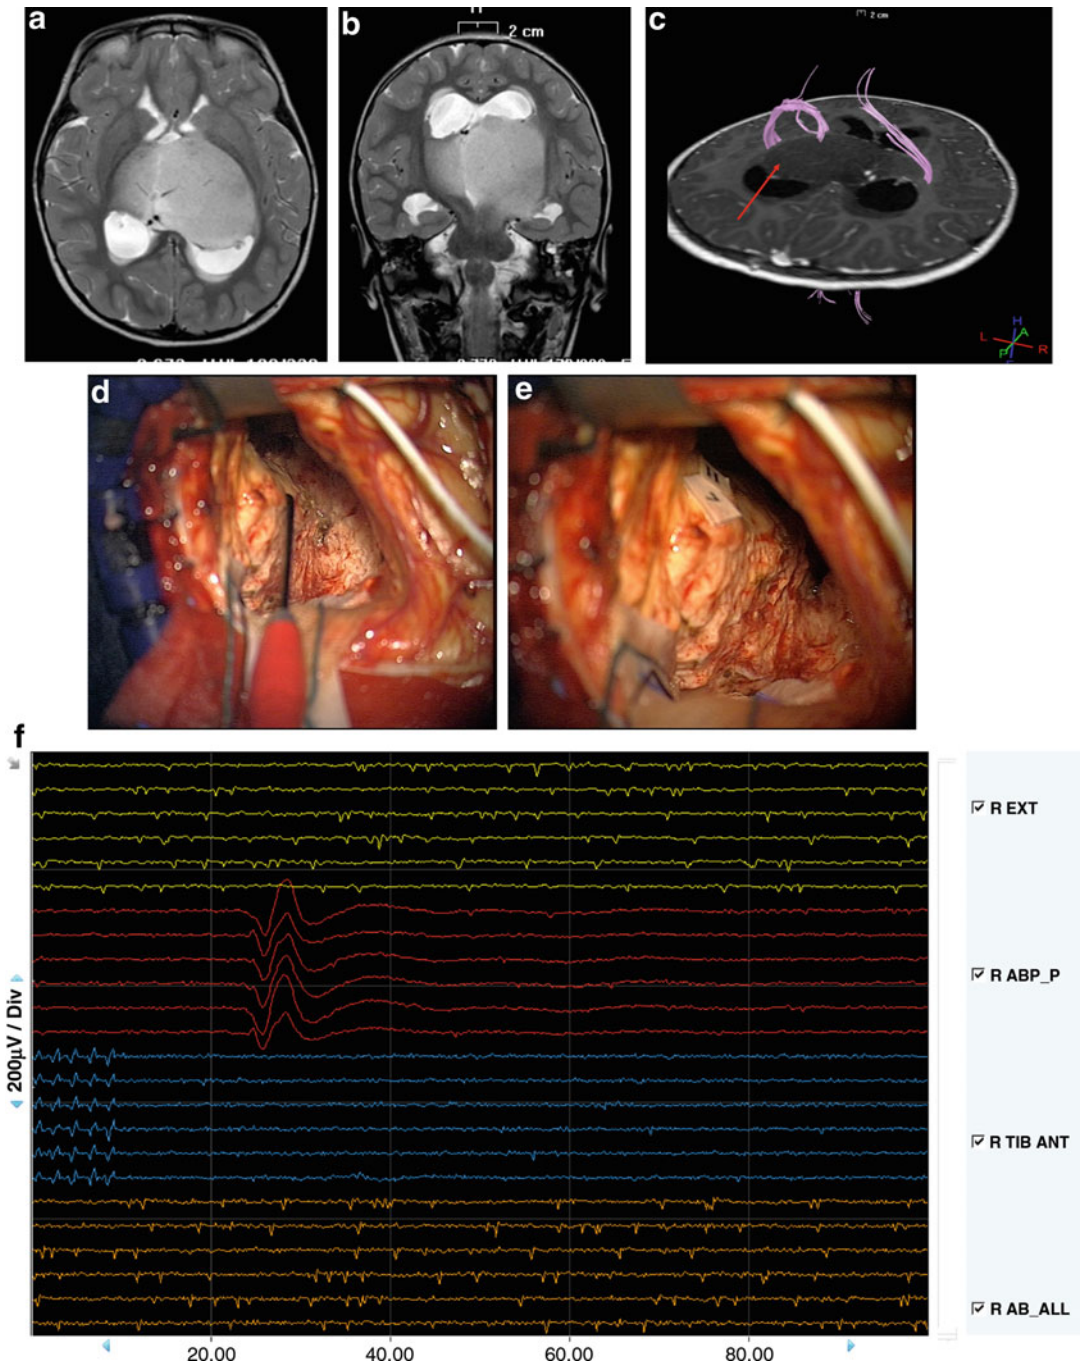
(a–b) A T2-weighted MRI (axial and coronal views) showing a large bilateral thalamic tumor in a 2-year-old girl, who presented with a progressive history of delayed milestones achievement, mild right hemiparesis, and tremor on the right upper limb. (c) Intraoperative neuronavigation snapshot. The tractography shows the corticospinal tract (*pink*) laterally displaced by
